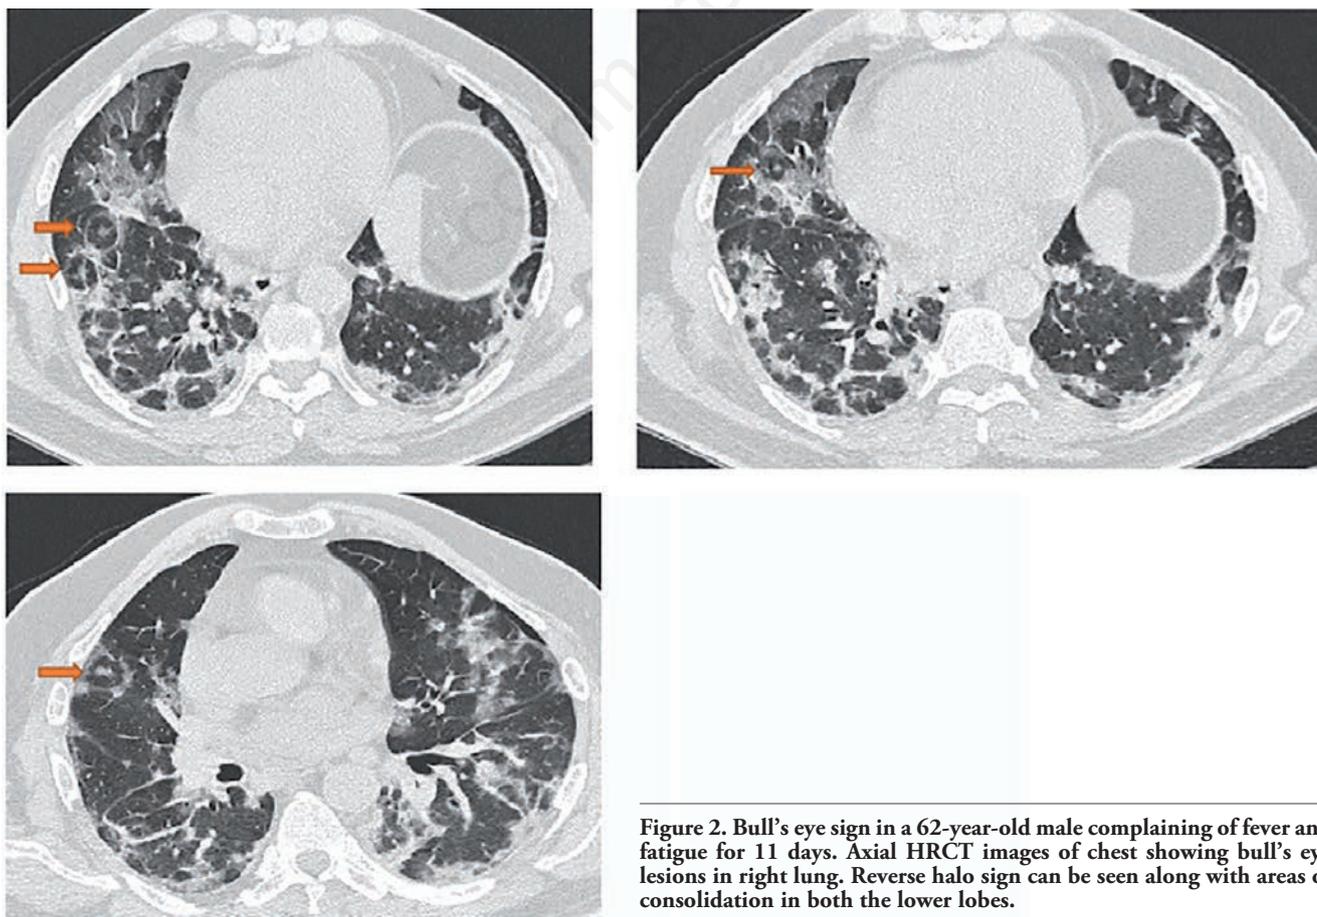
Bull's eye sign in a 62-year-old male complaining of fever and fatigue for 11 days. Axial HRCT images of chest showing bull's eye lesions in right lung. Reverse halo sign can be seen along with areas of consolidation in both the lower lobes.
